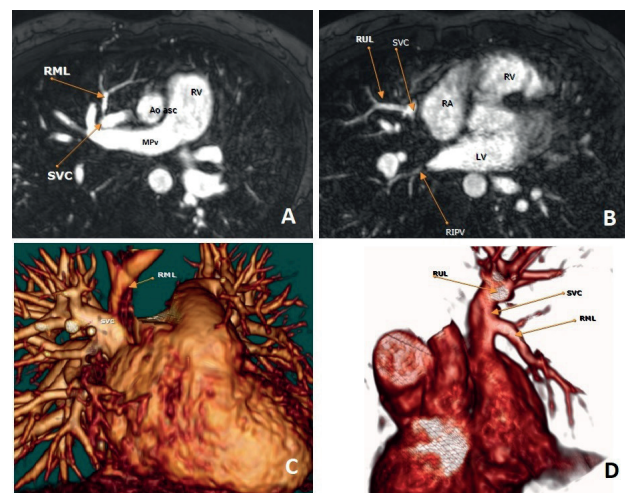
CMR. PAPVR from the right upper and medium lobes to the mid SVC. (A) Axial plane magnetic resonance imaging (MRI) angiographic image shows the right middle lobe accessory pulmonary vein drainage into SVC; (B) the same plane angiographic image present right upper lobe accessory pulmonary vein attached to SVC; (C and D) 3D virtual reality MRI image shows the right middle lobe and right upper lobe accessory pulmonary veins attached to SVC.
